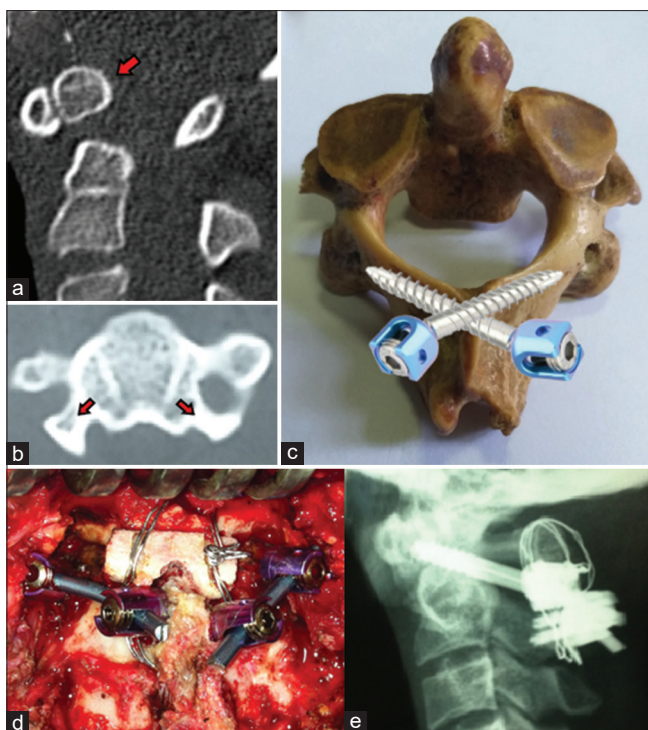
Imaging from case 7; female of 25 years old with Os odontoideum. (a) Sagittal computed tomography showing the Os odontoideum. (b) Axial computed tomography passing through C2; the arrows show the relatively narrow pedicles limiting trans-pedicular screwing. (c) Image of superposition explaining screws placement in bilateral crossing C2 laminar screws technique, our alternative for this case since pedicle screwing is risky. (d) Per-operative photography showing screws placement on C1 lateral masses and laminae of C2; it also shows the bone graft placement between the posterior arch of C1 and spinous process of C2; hold in place by classic wiring technique. (e) Postoperative lateral X-rays showing the construct placement
